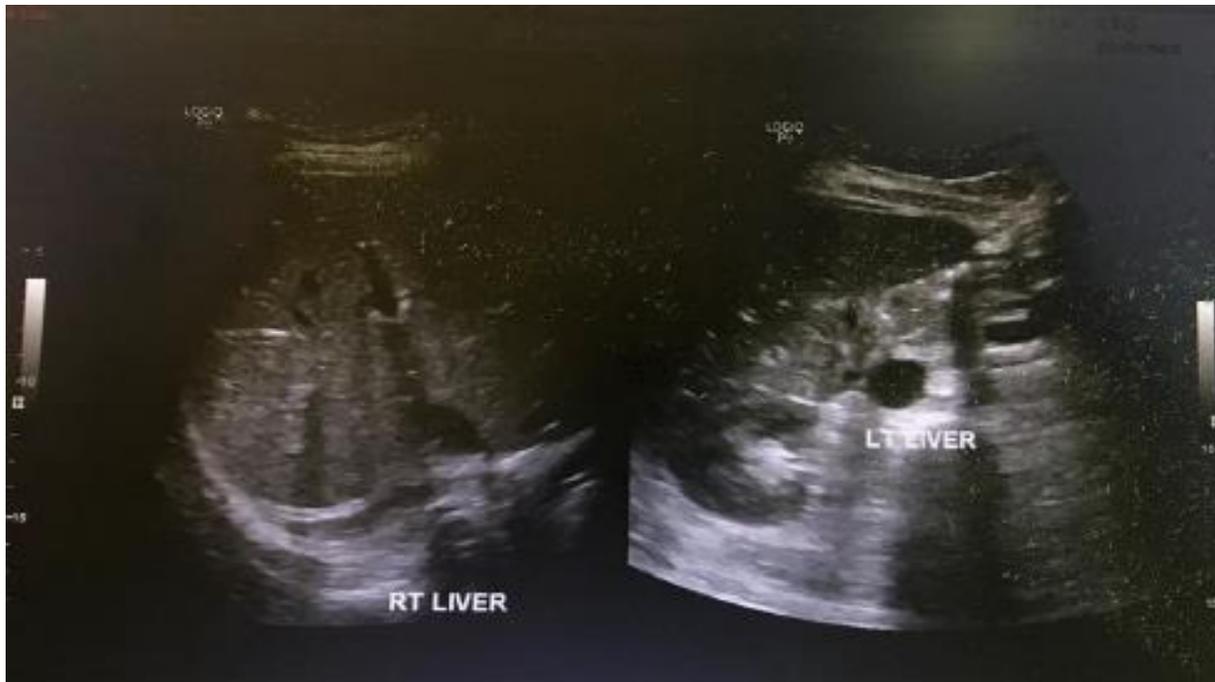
Ultrasound showing hepatomegaly without evidence of biliary obstruction
